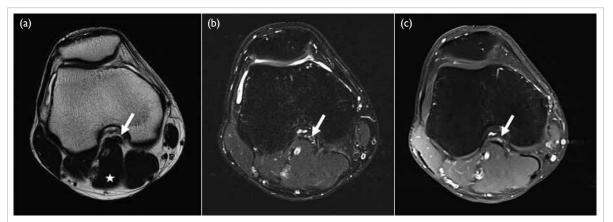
Magnetic resonance image of the knee. (a) T2-weighted, (b) T2-weight fat saturated and (c) T1-weighted fat-saturated post-contrast images showing popliteal artery (white arrows) passing medial to and underneath the medial head of the gastrocnemius. It is severely compressed between the medial head of the gastrocnemius (asterisk) and distal femur into a slit-like configuration. Findings are consistent with popliteal artery entrapment syndrome
